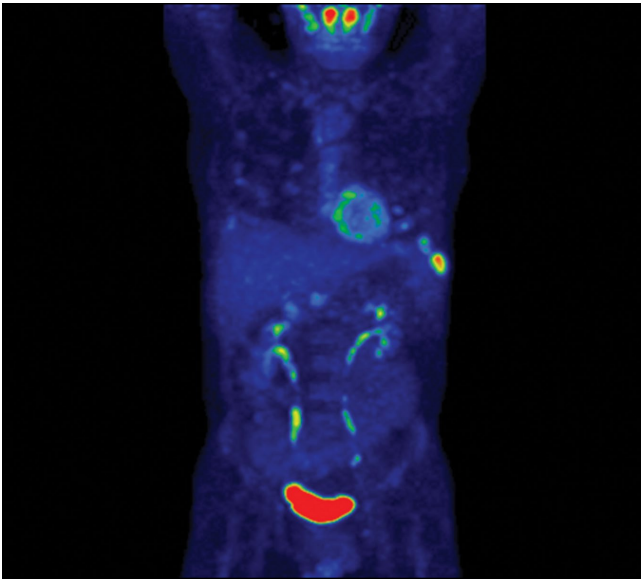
Three dimensional maximum intensity projection (MIP) 18F FDG PET demonstrating tracer activity in lymph nodes in the neck, and several foci in the lungs and costae. Physiological activity in the heart, kidneys, and bladder.
